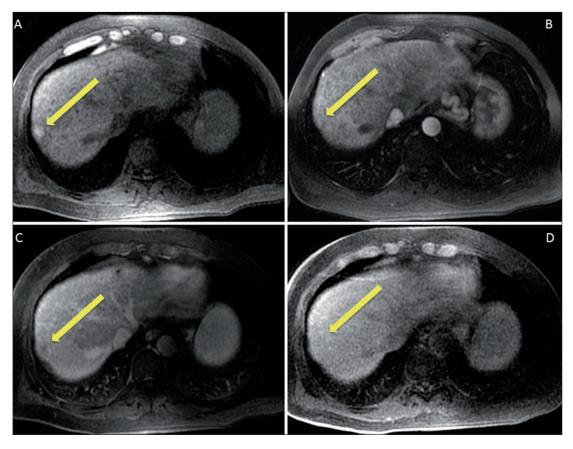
Low-grade dysplastic nodule (LGDN). A, T1-weighted axial image shows an hyperintense nodule on the lateral margin of the VIII hepatic segment. B, At dynamic imaging, in the arterial phase, no hypervascularity is shown. C, The nodule is slightly hypointense in the venous phase. D, In delayed phase imaging, the nodule is isointense relative to surrounding liver parenchyma.
